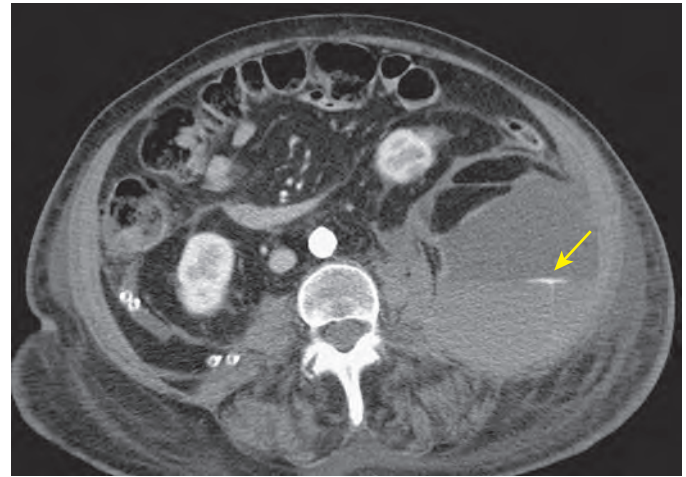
Spontaneous retroperitoneal bleed: CT features. Active extravasation of contrast material (arrow) is identified in the left flank of this patient who was overly anticoagulated. Blood is identified in multiple spaces: retroperitoneal, extraperitoneal, and interfascial.
